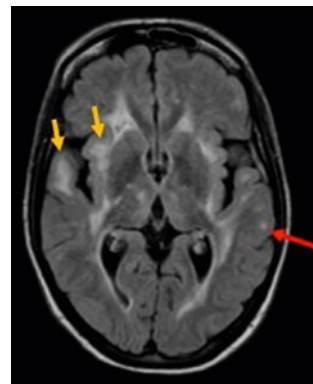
Axial Cranial MRI. FLAIR. Anterior temporal lobe and diffuse extensive leukopathy suggestive of CADASIL (yellow arrow). Juxtacortical lesions (red arrow) typical in MS.
